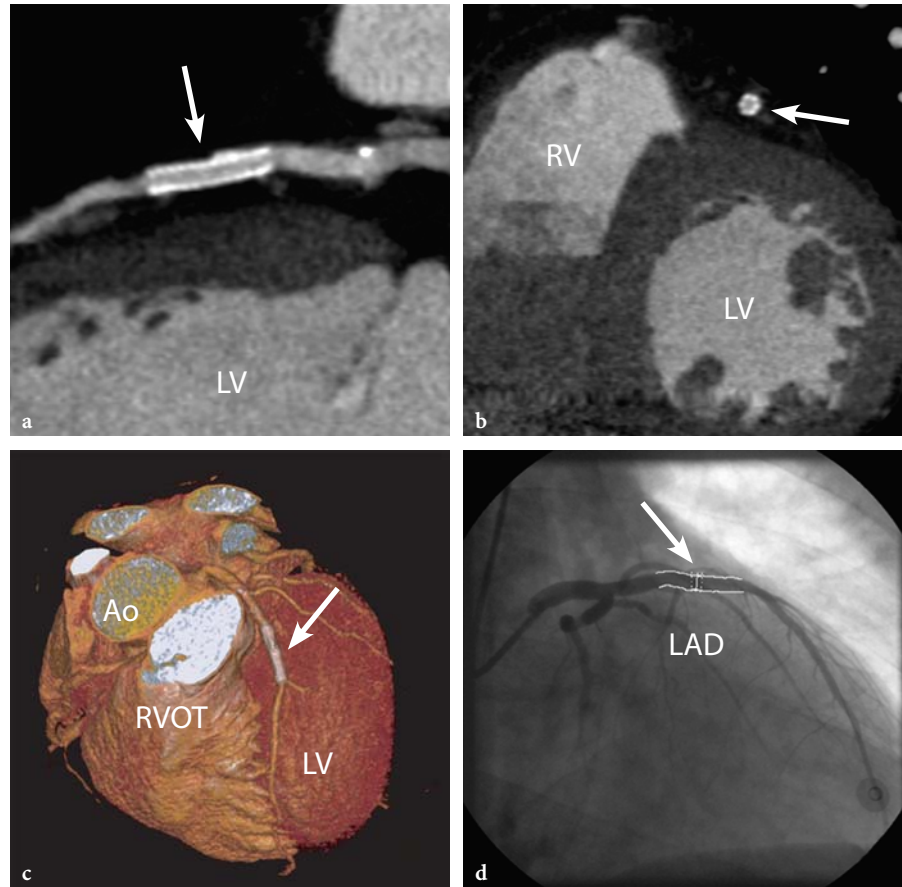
Patent stent in the LAD, examined with 64-slice CT. Curved MPR (a) and cross-sectional MPR (b) reveals a patent lumen without the presence of stenosis. VRT reconstruction demonstrates the run-off of the native vessel (c). Conventional angiography confirms the 64-slice CT findings (d). (Case courtesy of Grosshadern Clinic, University of Munich, Germany)
